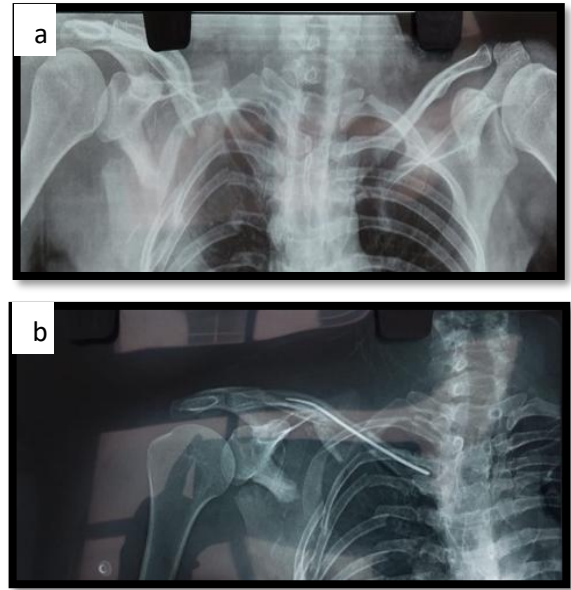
(a, b): Pre-operative X-ray of a 32-year-old female with right sided mid shaft clavicle fracture following road traffic accident. Post-operative X-ray showing fracture fixation done with TENS nail.
